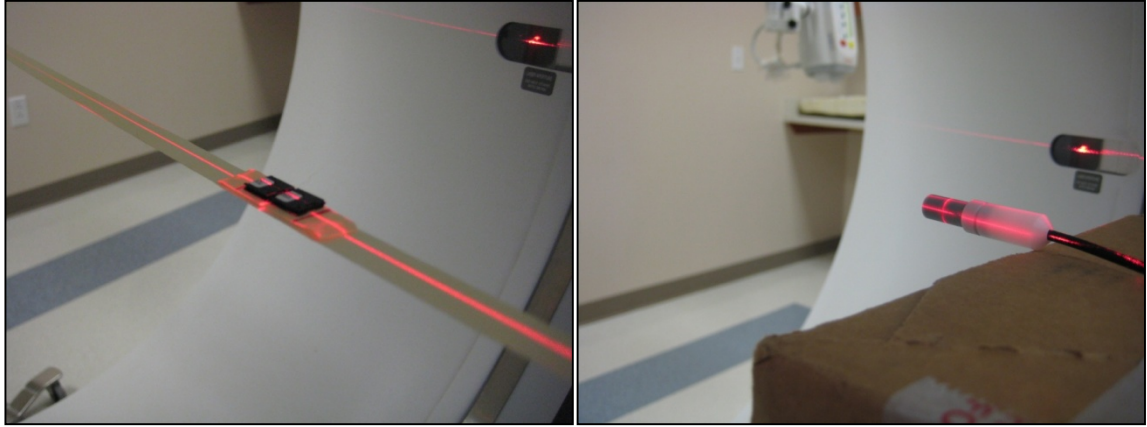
(a) OSLD setup for free-in-air CT calibration; (b) ion chamber setup using empty cardboard box for free-in-air calibration
